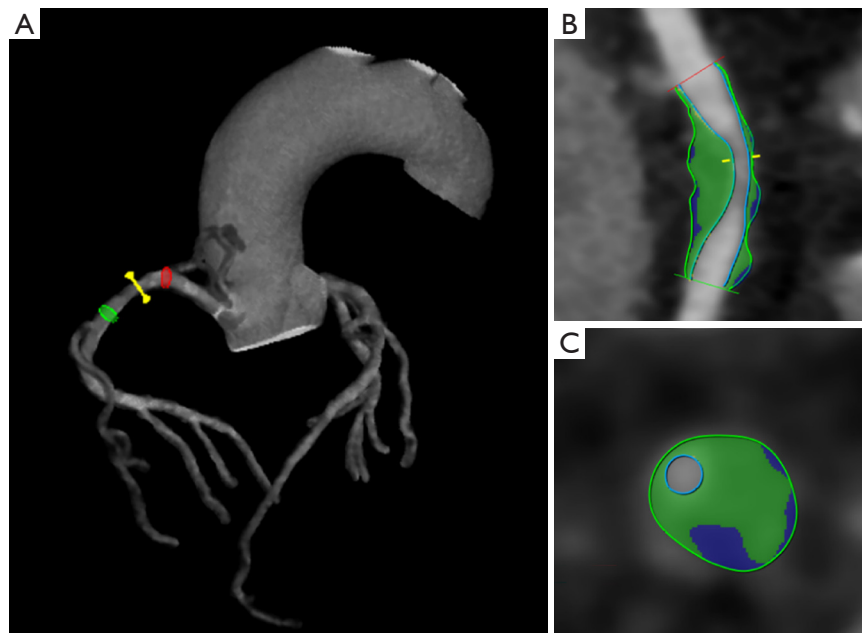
A 60-year-old man infected with HIV. The reconstruction images of CCTA display a noncalcified plaque in the RCA, with lumen stenosis of more than 70% and a plaque volume of 317.98 mm³. (A,B) The red line marks the proximal end of the plaque; the green line marks the distal end of the plaque; and the yellow line marks the minimum luminal area, where the stenosis is maximum. (C) Cross-sectional image of the plaque at the position indicated by the yellow line in (B). Green indicates intermediate-attenuation plaque (31–130 HU). Blue indicates low-attenuation plaque (<30 HU). HIV, human immunodeficiency virus; CCTA, coronary computed tomography angiography; RCA, right coronary artery; HU, Hounsfield units.
